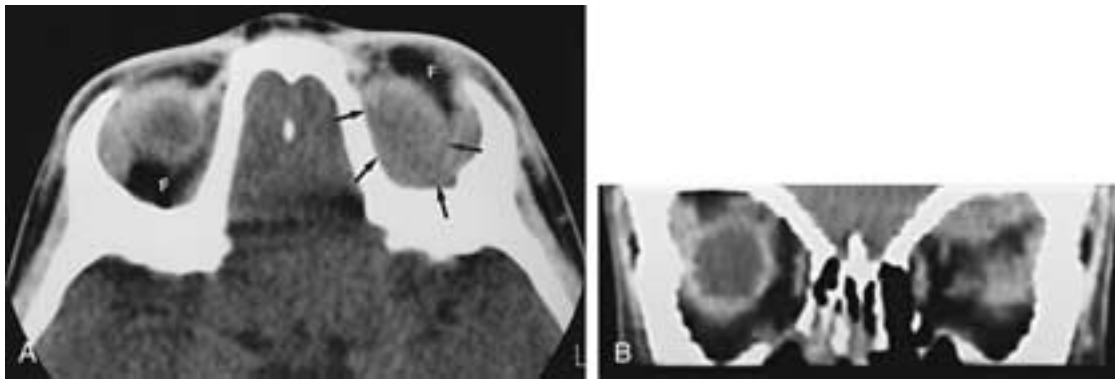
Subacute subperiosteal hematoma (less than 7 days). A, Axial CT scan of the orbit in a 2-year-old child. Note the subacute subperiosteal hematoma (arrows) and displacement of the peripheral orbital fat (F). B, Coronal reformatted images of the same patient showing the subacute hematoma. (From Dobben GD et al. Orbital subperiosteal hematoma, cholesterol granuloma, and infection. Evaluation with MR imaging and CT. Radiol Clin North Am 1998;36:1185–1200.)
